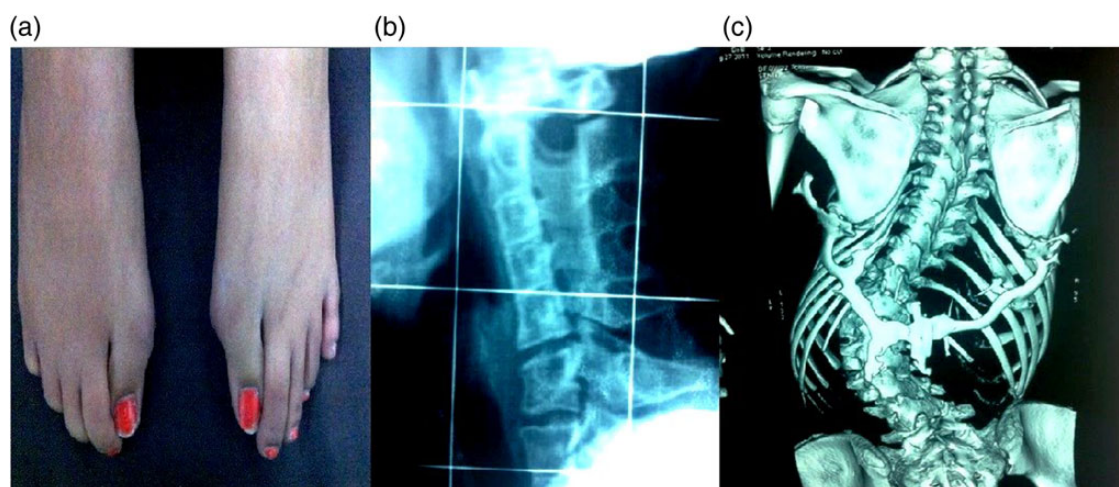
(a) Characteristic malformed great toe and hallux valgus. (b) The cervical skiagram shows large posterior elements and fusion of the facet joints between C2 and C7. (c) A CT scan of dorso-lumbar spine shows Y-shaped soft tissue ossification extending from the inferior angle of bilateral scapula to the midline soft tissue of posterior back (lattissimus dorsi muscles and thoracolumbar fascia), dorso-lumbar scoliosis with convexity to left, squaring of thoracic and vertebral bodies and fusion of posterior elements of thoracic and lumbar vertebrae.
